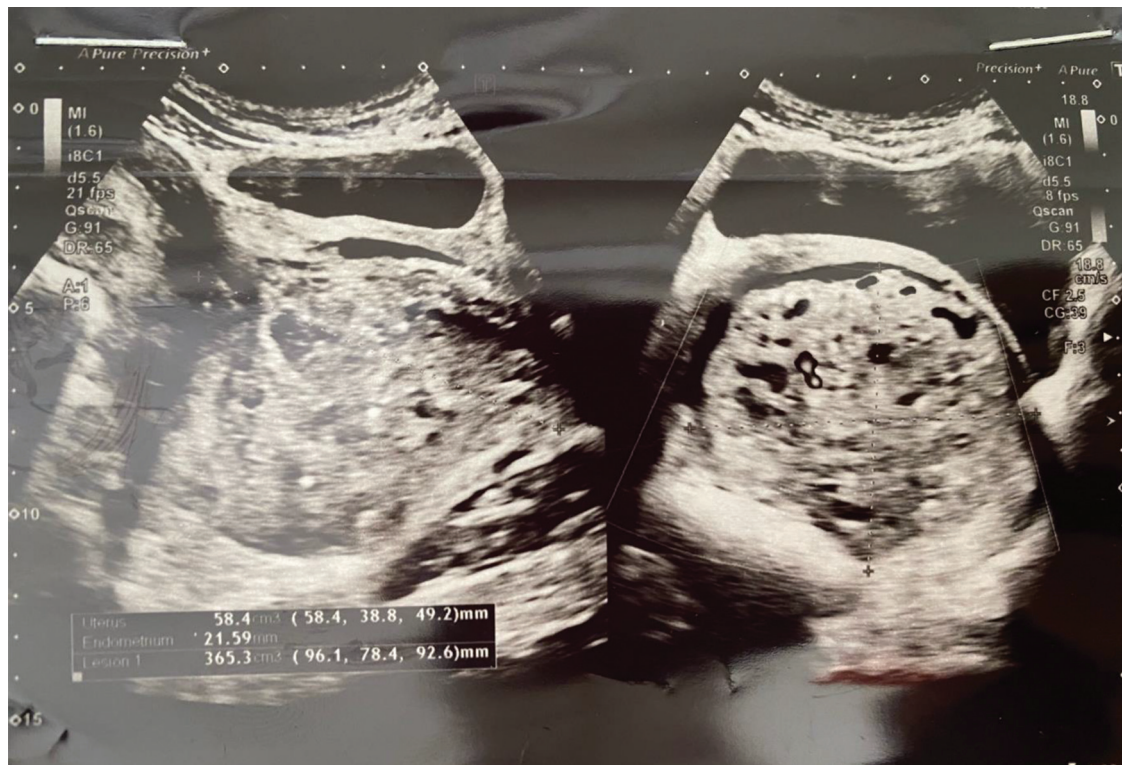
Ultrasound of the pelvis revealed an anteverted heterogenous uterus +/- 5.8 x 3.9 x 4.9cm with a thickened echogenic endometrium of +/- 2.2cm and a large solid-cystic mass with vascularity (main supply from the endometrial cavity) within the cervix and vagina (+/- 9.6 x 7.8 x 9.3cm). Multiple cysts (<1cm each) were noted in the left ovary (which measured 5.6 x 3.3 x 5.1cm). No cysts were noted in the right ovary which was otherwise normal (size: 3.4 x 3 x 3.1cm).
